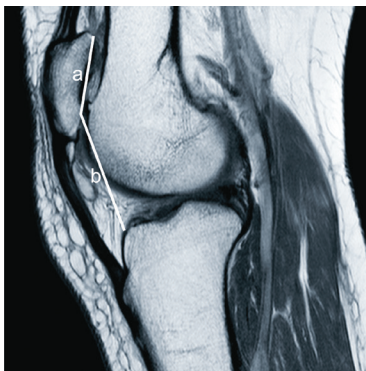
High patella, according to the Caton-Deschamps index, shown on T1-weighted MRI in the sagittal plane, in which the ratio between the line traced out from the lower pole of the patella to the anterior margin of the tibial plateau (line b) and the line from the joint margin of the patella (line a) is greater than 1.2.
